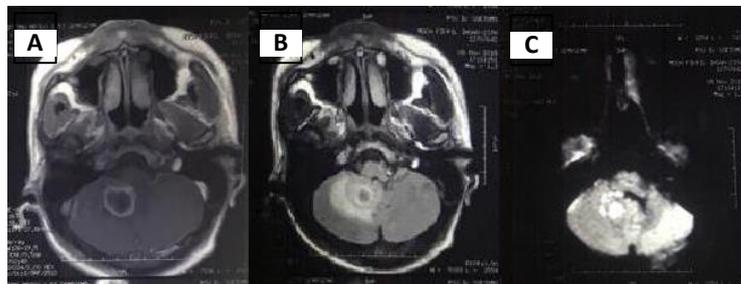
Brain MR-imaging in the T1-weighted image. (A) revealed a ring-enhancing mass in the right cerebellar hemisphere. The FLAIR sequence; (B) revealed a ring-enhancing mass in the right cerebellar hemisphere with perifocal edema. In DWI sequence (C) revealed a restricted diffusion area.
